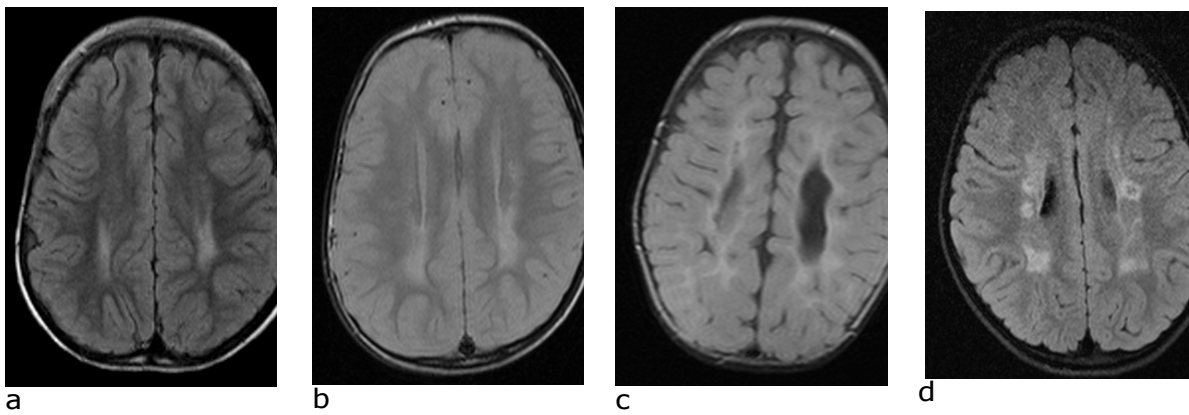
Axial FLAIR MRI: optic classification of the grade of the gliosis: a, gliosis grade 2; b, gliosis grade 3; c, gliosis grade 4; d, gliosis grade 5.
